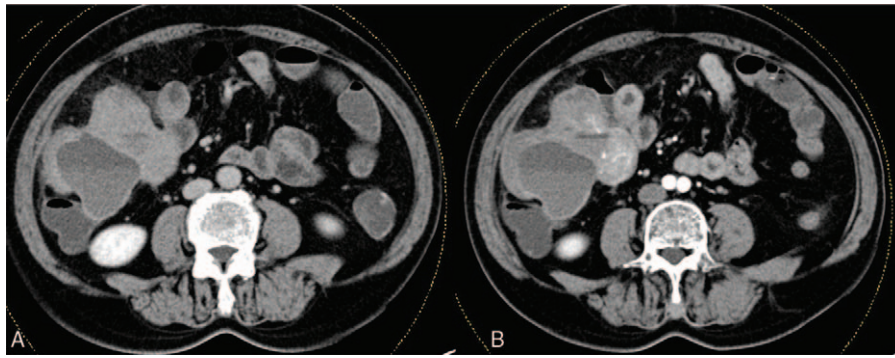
CT of the patient showing the mass of the right lower abdomen. Dynamic contrast-enhanced CT imaging showing a cyst-like area (A) and a solid area being hyperenhanced in the arterial phase (B). CT=computed tomography.
